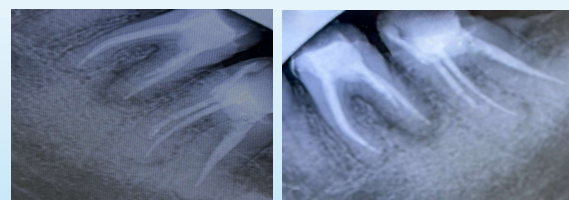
Postoperative radiographs of both teeth obtained from different angulations
